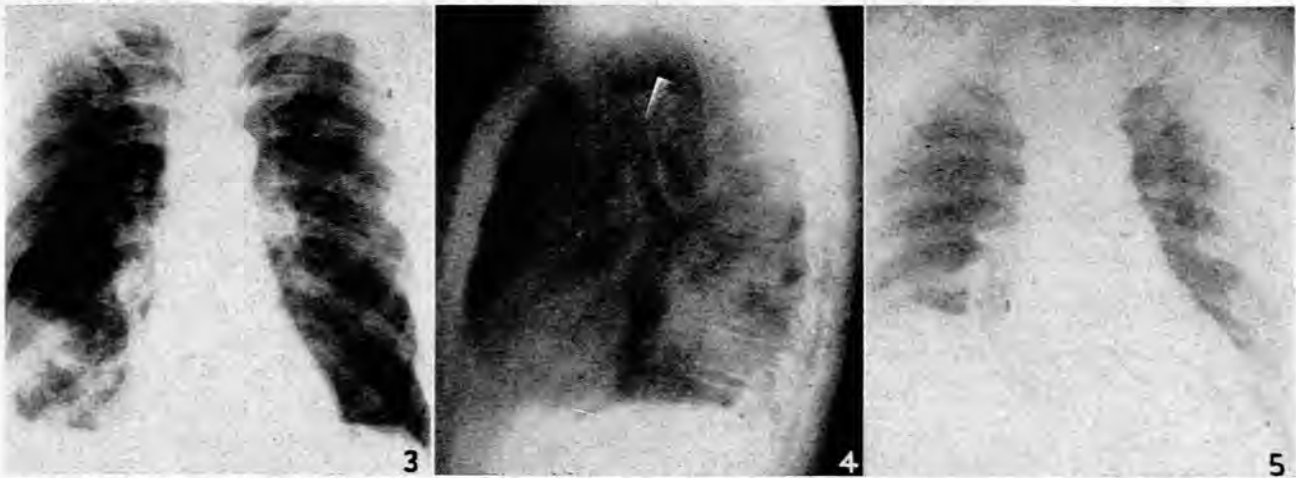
Case J.S. Chest radiograph in the postero-anterior plane showing a rounded opacity in the base of the right lung. There is also a small pleural effusion at the right base.
